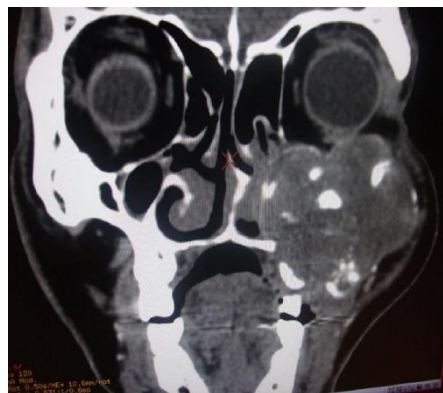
Computed tomography scan (coronal view) revealed lobulated expansile lesion involving the left maxillary sinus, floor of the orbit, lateral wall of the nose with presence of multiple foci of calcification
